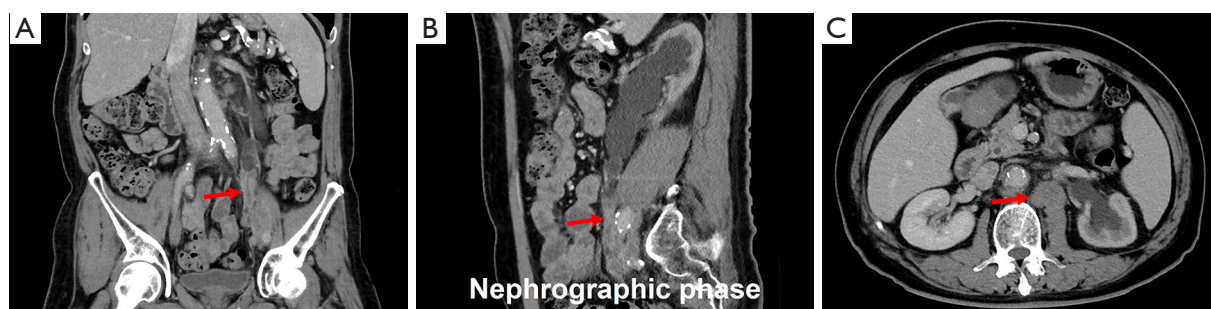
Computed tomography urography imaging of ureteral DSRCT after chemotherapy. (A,B) Coronal and sagittal images from the nephrographic phase revealed a significant reduction in the size of the ureteral lesion (long arrows). (C) The size of the lymph nodes (long arrow) adjacent to the abdominal aorta had significantly diminished compared to the previous assessment, and necrosis and cystic changes were apparent in the lymph nodes. DSRCT, desmoplastic small round cell tumor.
